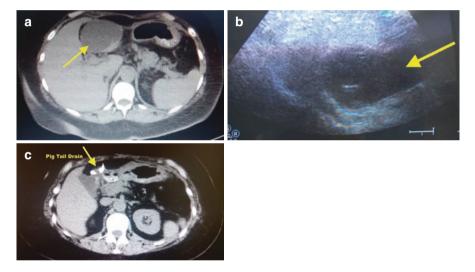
CT scan (a) and ultrasound (b) showing in yellow arrow the abscess. (c) The pigtail drain
